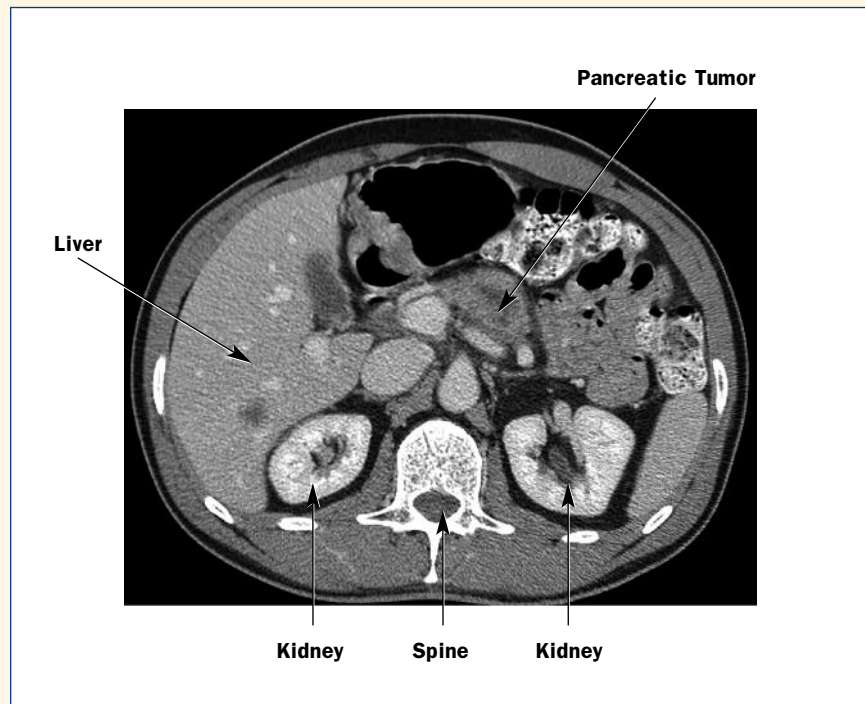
Computed tomography scan of the abdomen showing a pancreatic tumor.
